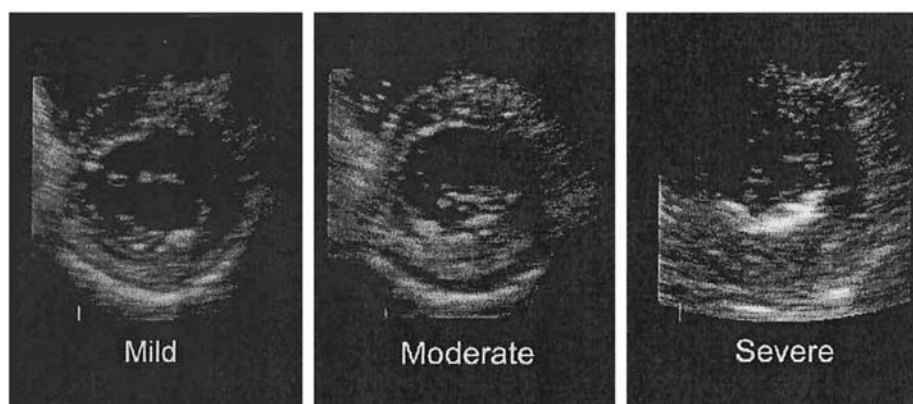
Degree of MAC in parasternal short axis view.
